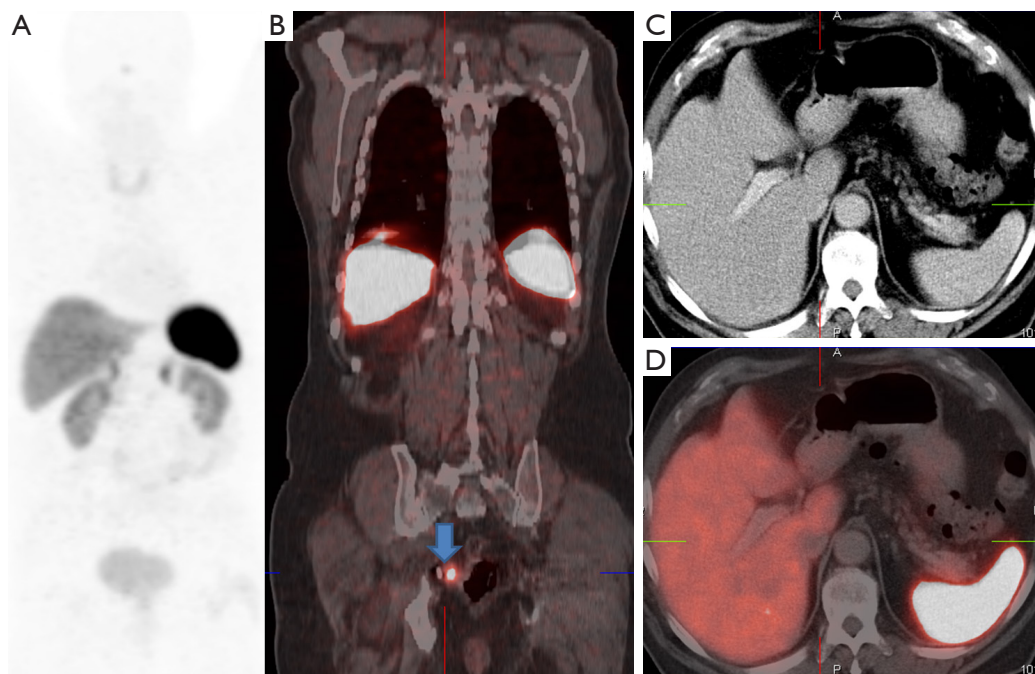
The corresponding images (when compared with *Figure 3*) of the Ga-68 SSTR PET/CT after PRRT demonstrate complete remission of the liver metastases and partial remission of the primary rectosigmoid tumor (arrow) according to molecular response criteria (there was a 85 % decrease in the target-to-spleen SUV ratio).
